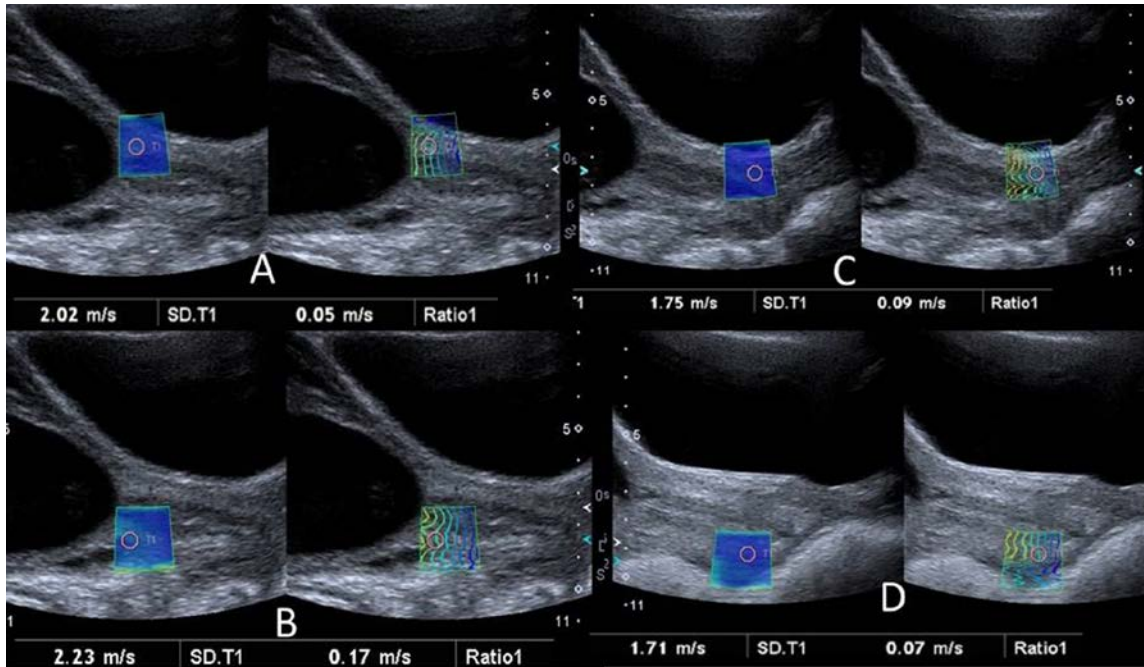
Example of elastogram and ROI placement for the transabdominal ultrasound approach. SWS (and SD) obtained as follows: A - Anterior Internal os 2.02m/s (SD 0.05m/s), B - Posterior Internal os 2.23m/s (SD 0.17m/s), C - Anterior External os 1.75m/s (SD 0.09m/s), D - Posterior External os 1.71m/s (SD 0.07m/s).
